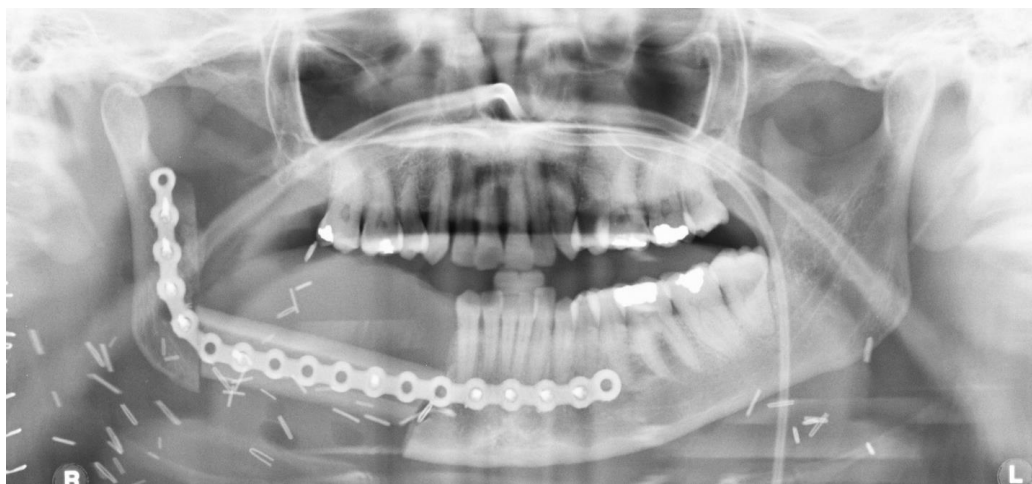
Orthopantomogram (OPT) showing single-barrelled fibula free flap set to height of remaining native alveolar bone to optimize implant-supported prosthodontic rehabilitation.
